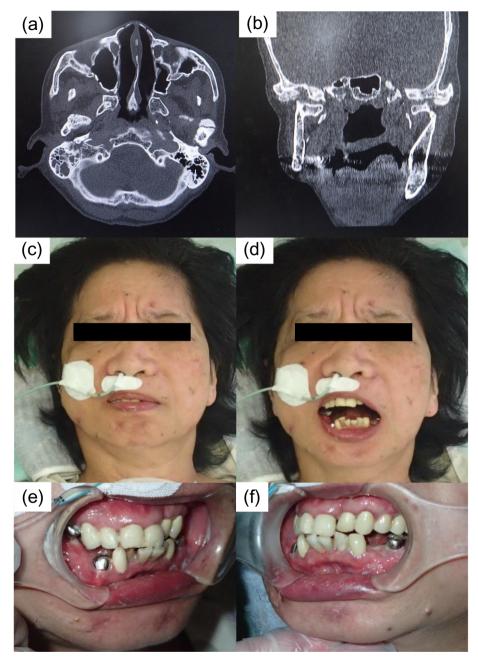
Axial (a) and coronal view (b) of postoperative CT showed acceptable reduction of the bilateral maxilla and mandibular ramus. Frontal appearance of the closed mouth (c) and open mouth (d) at eight weeks postoperatively. Dentition views (e) (f) showed the occlusal conditions before orthodontic therapy.
